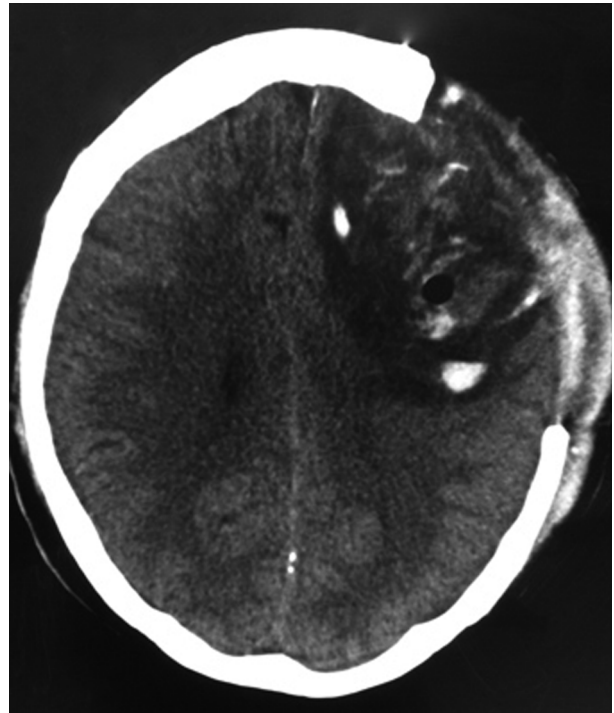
CT brain demonstrating left frontal MCA territory ischaemic stroke with haemorrhagic transformation.
